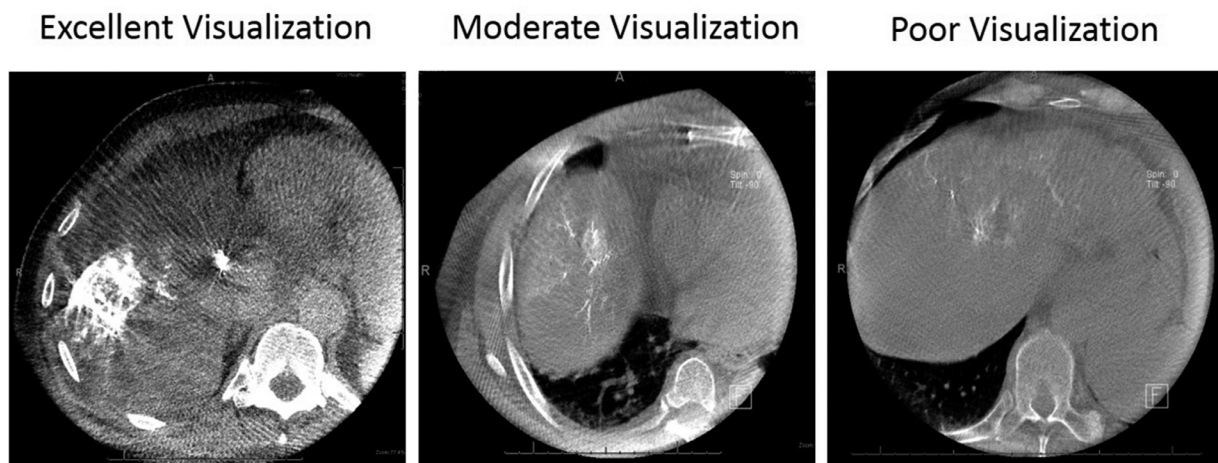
Initial post-TACE CBCTs showing an example each of excellent, moderate and poor visualization of LC Bead LUMI. Abbreviations: CBCT = cone beam computed tomography; TACE = transarterial chemoembolization.
